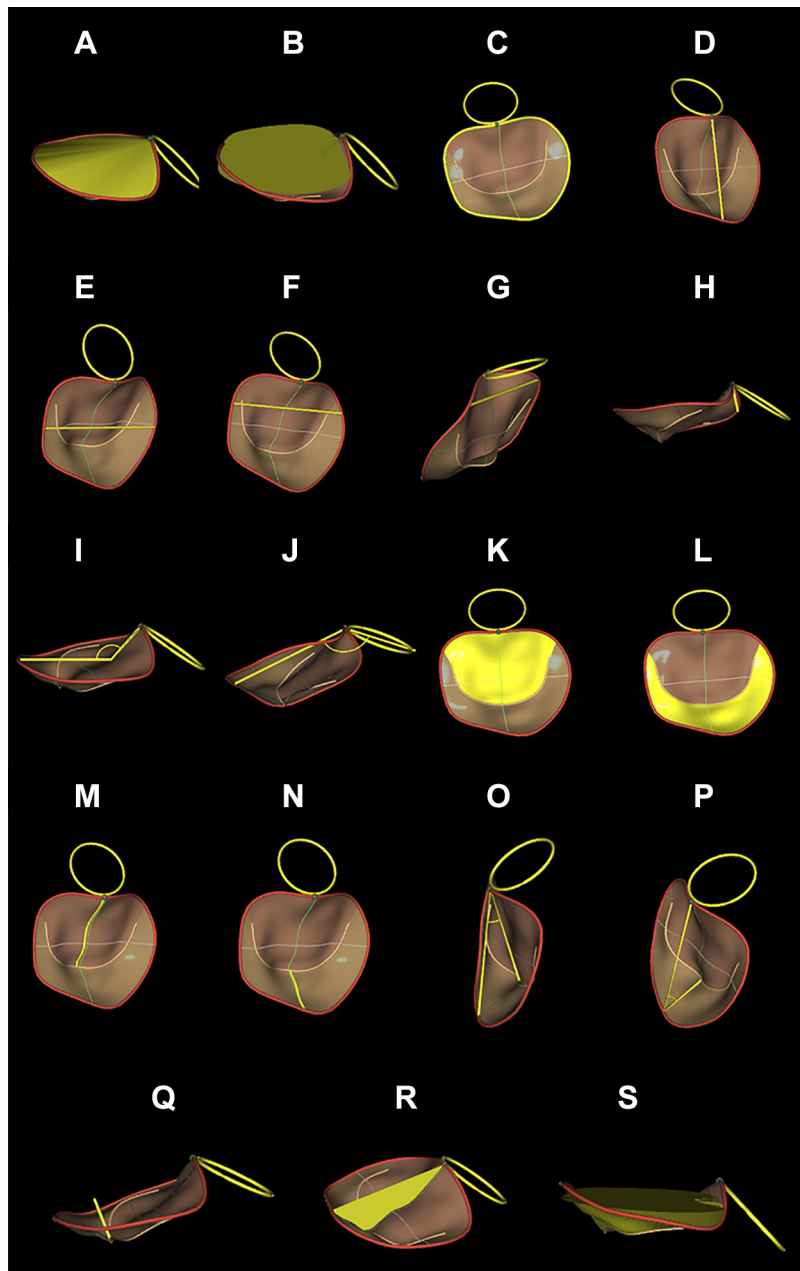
Graphical representation of the three-dimensional (3-D) echocardiography-derived measurements concerning the mitral valve. *A*: annulus 3-D area. The yellow surface represents the adjusted 3-D area of the mitral annulus. *B*: annulus two-dimensional (2-D) area. The yellow surface represents the projected area at the level of best-fit plane of the mitral annulus. *C*: annulus perimeter. The yellow line represents the circumference of the mitral annulus. *D*: anteroposterior diameter. The yellow line represents the distance between the anterior and posterior reference points of the mitral annulus. *E*: posteromedial-anterolateral diameter. The yellow line represents the longest distance between the posteromedial and the anterolateral reference points of the mitral annulus. *F*: commissural diameter. The yellow line represents the distance between the annular points at the level of the commissures. *G*: intertrigonal distance. The yellow line represents the distance between the points at which the anterior leaflet attached to the fibrous skeleton of the heart between trigones. *H*: annulus height. The yellow line represents the distance between the highest point and the lowest point of the mitral annulus. *I*: non-planar angle. The angle enclosed by the two yellow lines is used to calculate the nonplanar angle that describes the saddle shape of the mitral annulus. *J*: mitral-aortic angle. The angle enclosed by the two yellow lines (axes of aortic and mitral annuli) is used to calculate the mitral-aortic angle. *K*: anterior leaflet area. The yellow surface represents the area of the anterior mitral valve leaflet. *L*: posterior leaflet area. The yellow surface represents the area of the posterior mitral valve leaflet. *M*: anterior leaflet length. The yellow line represents the central contour line from which leaflet length is calculated. *N*: posterior leaflet length. The yellow line represents the central contour line from which leaflet length is calculated. *O*: anterior leaflet angle. The angle enclosed by the two yellow lines is used to calculate the anterior mitral valve leaflet angle. *P*: posterior leaflet angle. The angle enclosed by the two yellow lines is used to calculate the posterior mitral valve leaflet angle. *Q*: tenting height. The highlighted yellow line shows the central maximal distance between the mitral annular plane and the leaflet coaptation point. *R*: tenting area. The highlighted yellow surface shows the maximal area between the mitral annular anteroposterior axis and the central leaflet coaptation point. *S*: tenting volume. The yellow surface represents the volume enclosed between the mitral annulus and the mitral valve leaflets.
